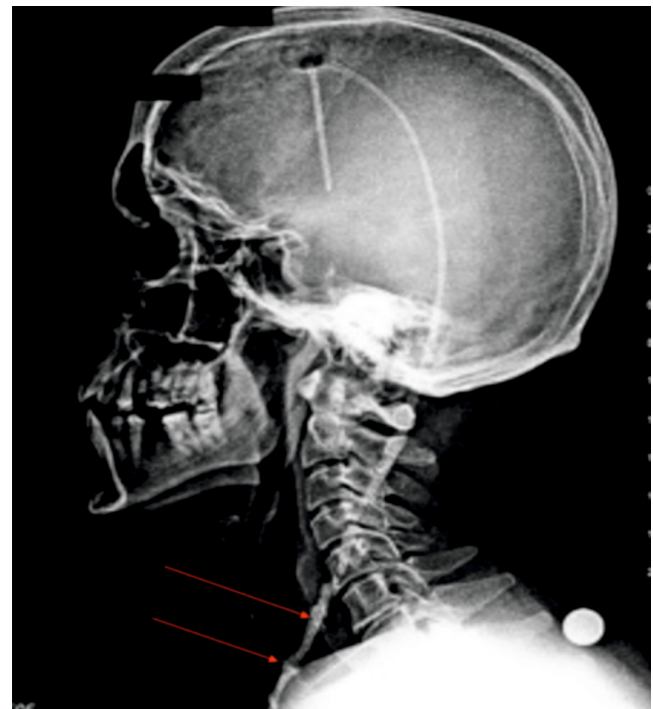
Preoperative plain radiograph showing the calcified shunt trace with arrow.
